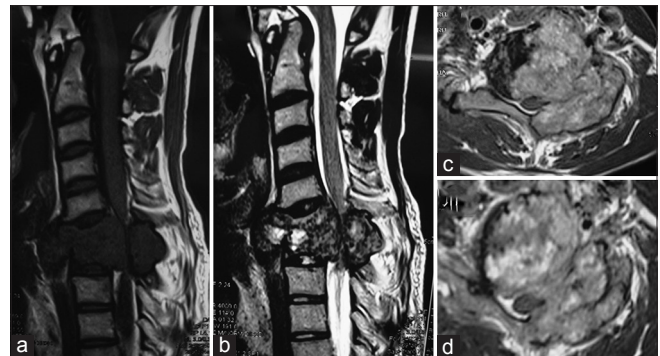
(a) T1-weighted1 saggital magnetic resonance imaging (MRI) showing isointense mass involving anterior and posterior elements of C6 vertebral with thecal sac compression. (b) T2-weighted saggital MRI showing isointense mass with slight hyperintensity involving anterior and posterior element of C6 vertebral body. (c and d) T1-weighted axial cuts of MRI with contrast showing mass involving anterior and posterior element of C6 vertebra with minimal contrast enhancement
